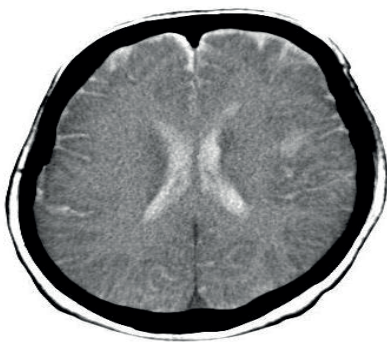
Ischemic stroke in left parietal lobe (computed tomography) in a patient with Gerstmann's syndrome
